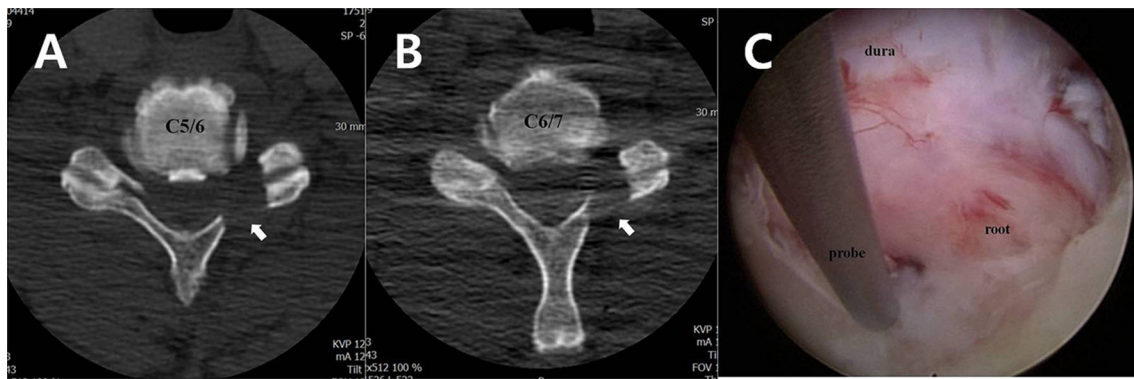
a, b Axial computed tomographic images after EPCF demonstrating the partial laminectomy and foraminotomy (white arrows) performed in a 49-year-old male with C5/6, C6/7 left-sided
